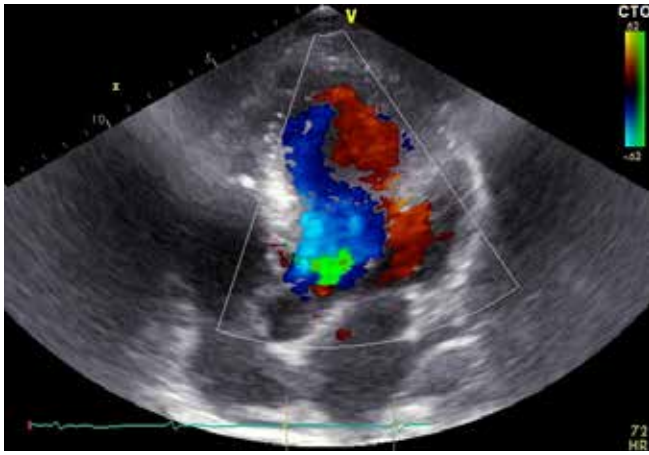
Echocardiographic image showing aortic regurgitation
